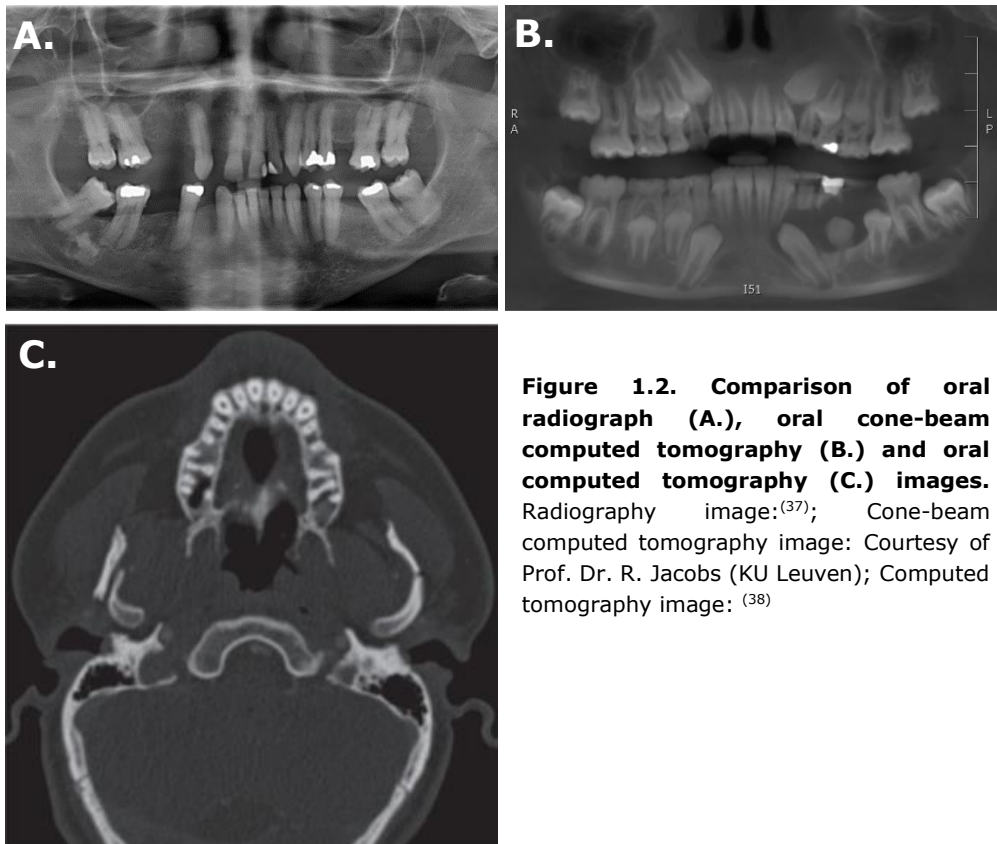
Comparison of oral radiograph (A.), oral cone-beam computed tomography (B.) and oral computed tomography (C.) images. Radiography image:⁽³⁷⁾ Cone-beam computed tomography image: Courtesy of Prof. Dr. R. Jacobs (KU Leuven); Computed tomography image: ⁽³⁸⁾
